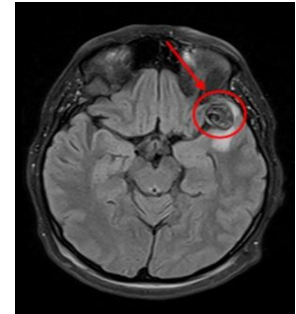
MRI FLAIR sequence
